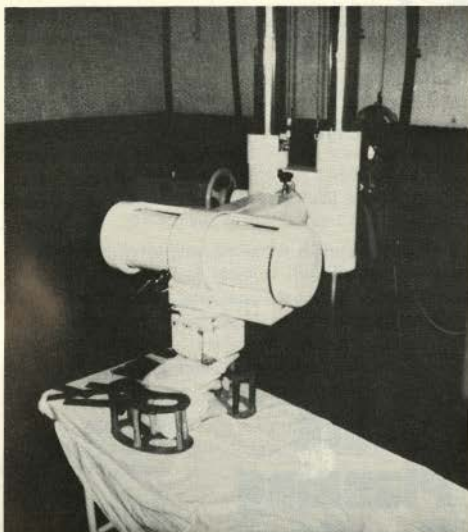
Chinese Manufactured 250 KV X-ray Therapy Unit
